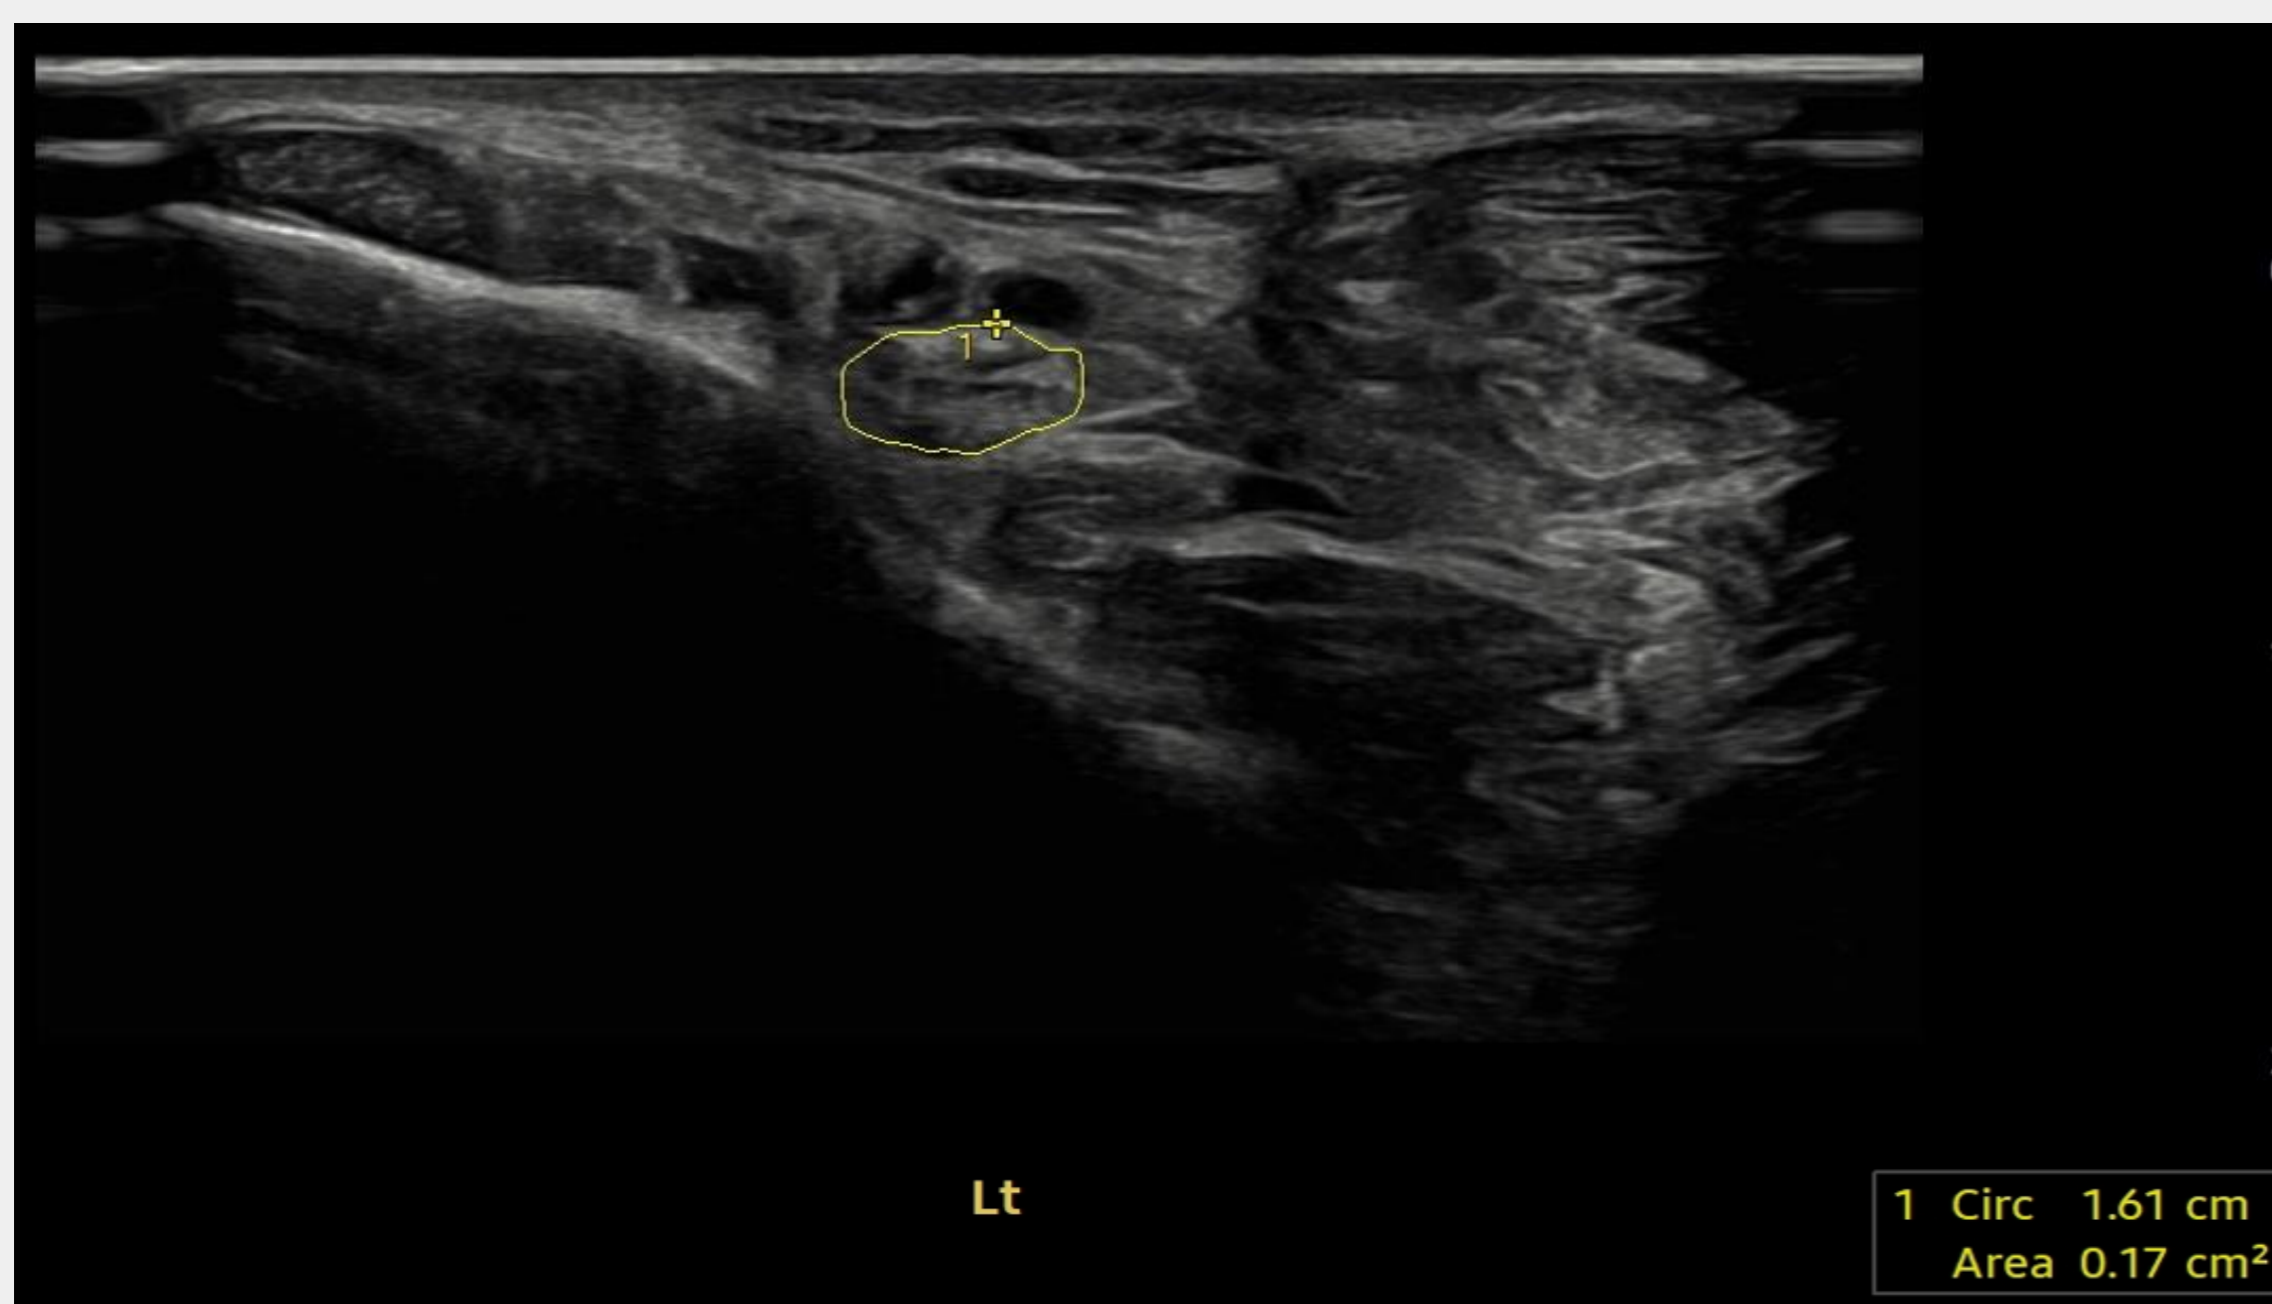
Axial ultrasound on the level of the medial malleolus showing enlargement of the left posterior tibial nerve with a cross-sectional area of 17 mm² (normal: <11 mm²; contralateral side: 8 mm²)
